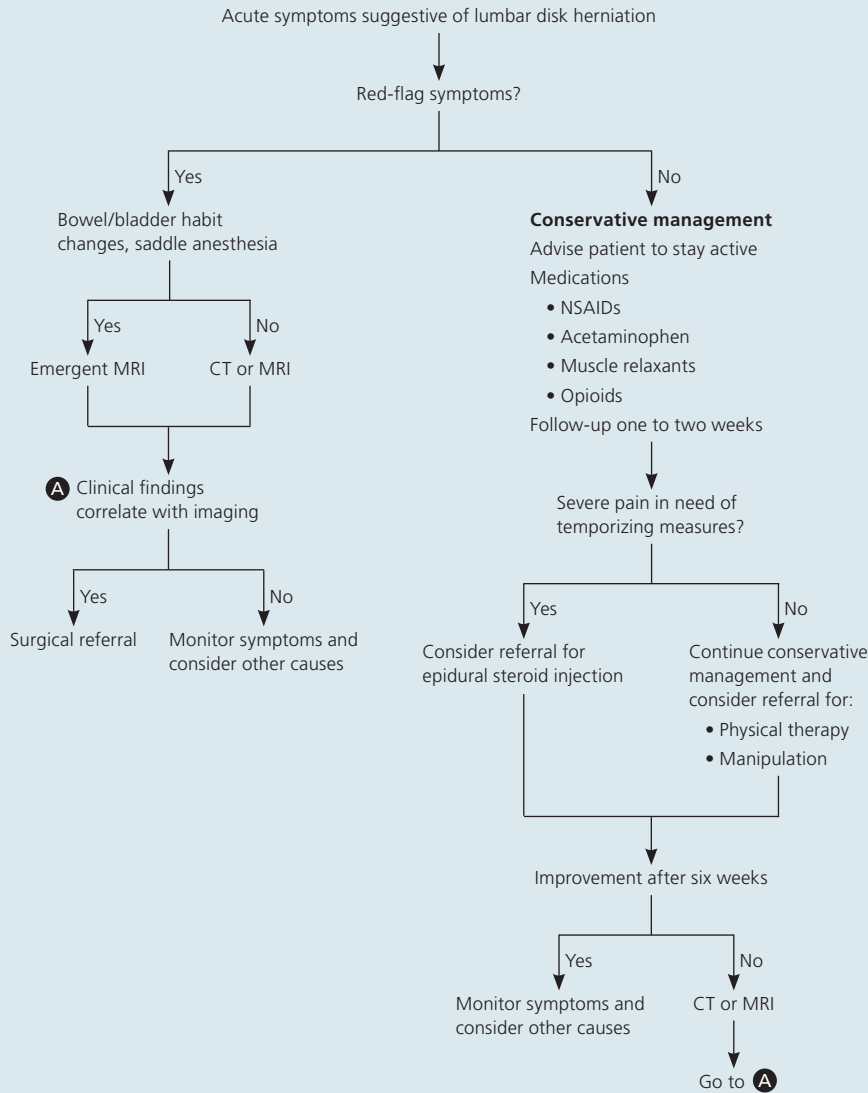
Algorithm for treatment of acute lumbar disk herniation. (CT = computed tomography; MRI = magnetic resonance imaging; NSAIDs = nonsteroidal anti-inflammatory drugs.)
